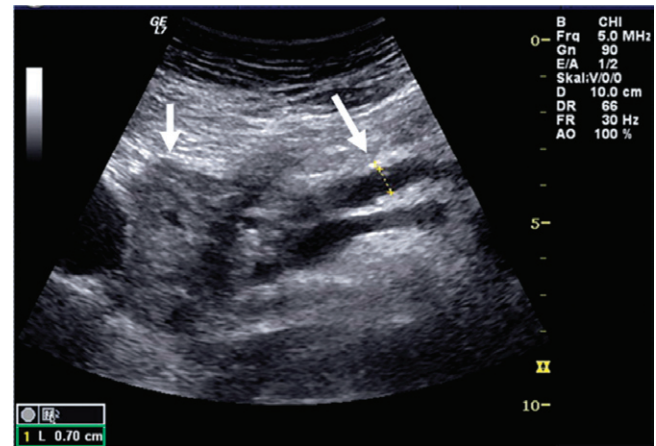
Inflammatory tumor of the pancreatic head. Transabdominal sonography: inflammatory tumor of the pancreatic head (short arrow) and dilated main pancreatic duct (long arrow).
